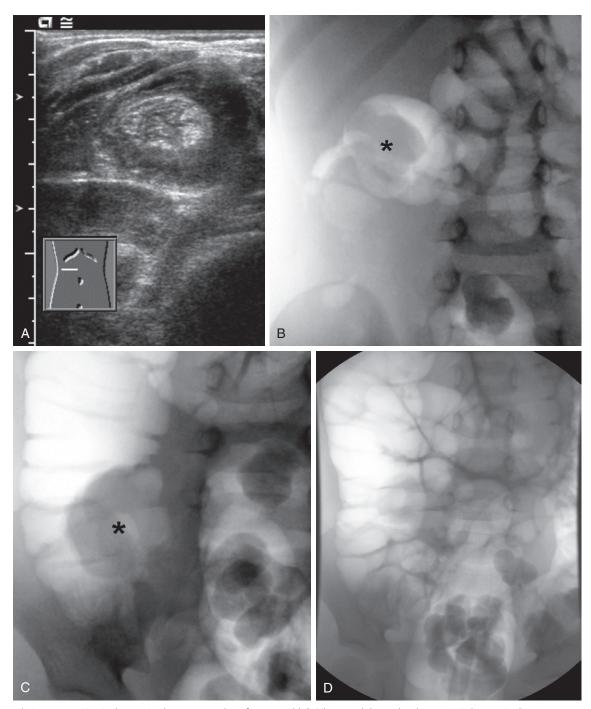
Ileocolic intussusception in the proximal transverse colon of a 2-year-old. A, Ultrasound shows the characteristic "target sign" on transverse section (hypoechoic ring with an echogenic center). B-D, Air enema reduction: B, Intussusception (*) is initially located in the right upper quadrant; C, intussusception (*) has moved retrograde and is now in the region of the ileocecal valve; D, successful reduction with resolution of the soft tissue mass and reflux of air into the terminal ileum.
